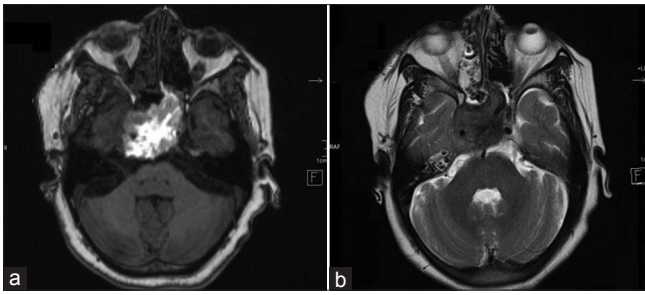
(a and b) Magnetic resonance images-T1 and T2 weighted axial sections of the brain (preoperative) showing altered signal intensity lesion with solid, hemorrhagic, and few cystic components in basiocciput, basisphenoid, clivus, sella, and right petrous apex; displacing optic chiasma superiorly associated with soft tissue component extending into cavernous sinus with partial encasement of cavernous segment of right internal carotid artery
